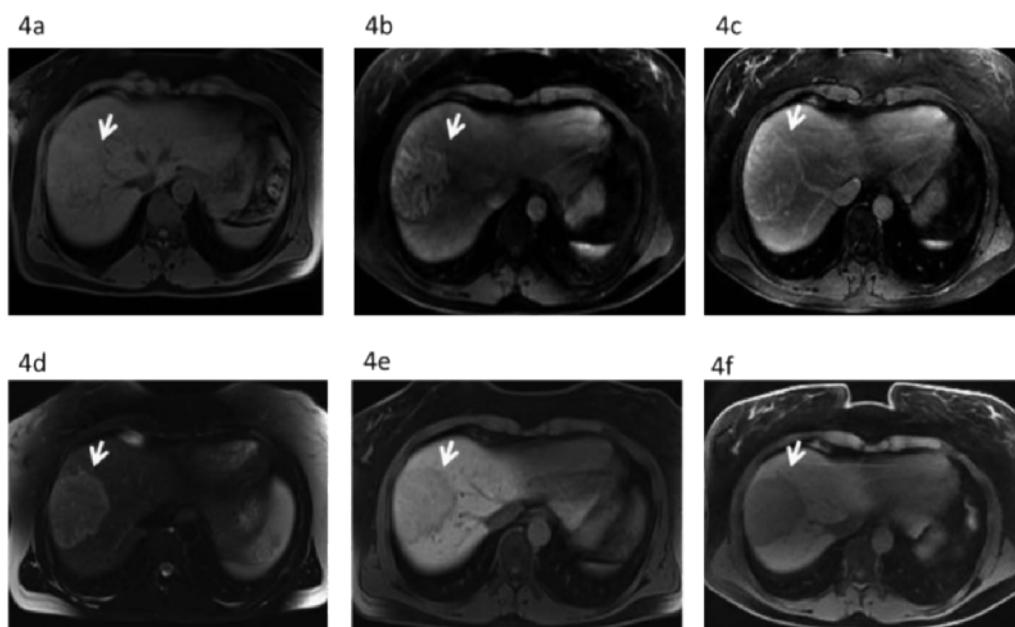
A premenopausal 50-year-old woman with an intermediate lesion (arrow) that regressed by more than 20% in maximal diameter over several months after cessation of oral contraceptives, a sign typical of HCA. The lesion is slightly hyperintense on T1-weighted imaging without intravenous contrast and with fat saturation (figure 3a). After intravenous contrast injection the lesion is hypervascular in the arterial phase (figure 3b) and slightly hyperintense in the venous phase (figure 3c). Furthermore, the lesion is slightly hyperintense on T2-weighted images (figure 3d). After intravenous injection of Gd-EOB-DTPA the lesion became hypointense in the hepatobiliary phase (figure 3e), whereas the lesion was hyperintense in the hepatobiliary phase after intravenous injection of Gd-BOPTA (figure 3f).
